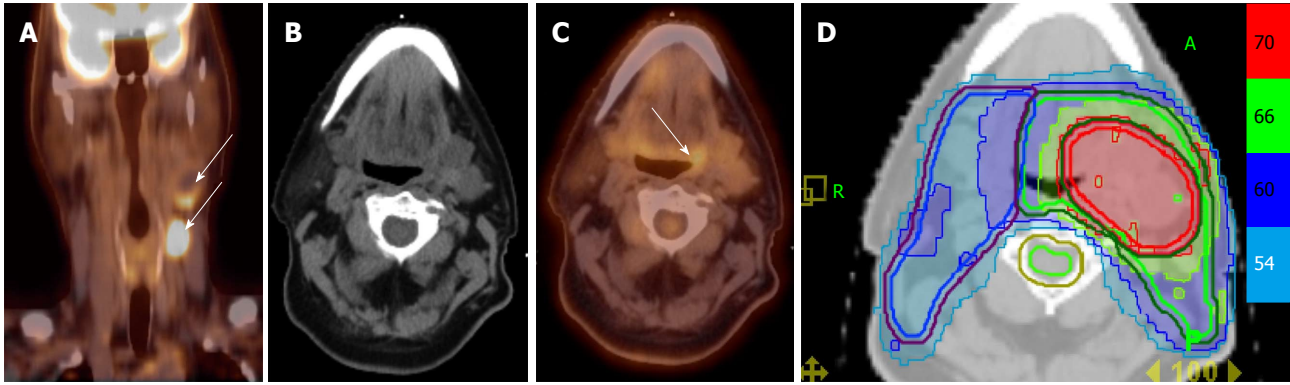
Positron emission tomography/computed tomography allows for detection for occult primary in a patient with multiple involved left neck nodes. A: PET/CT showing the initial presentation with multiple enlarged left neck nodes (white arrows); B: A conventional CT scan does not reveal a source of primary cancer; C: PET/CT demonstrated increased FDG uptake in the left base of tongue (white arrow) and a directed biopsy of this area revealed this as the primary site; D: IMRT treatment plan for this patient showing that the left base of tongue was included in the high-dose (70 Gy) volume while sparing uninvolved mucosal areas. IMRT: Intensity modulated radiation therapy; PET/CT: Positron emission tomography/computed tomography.
